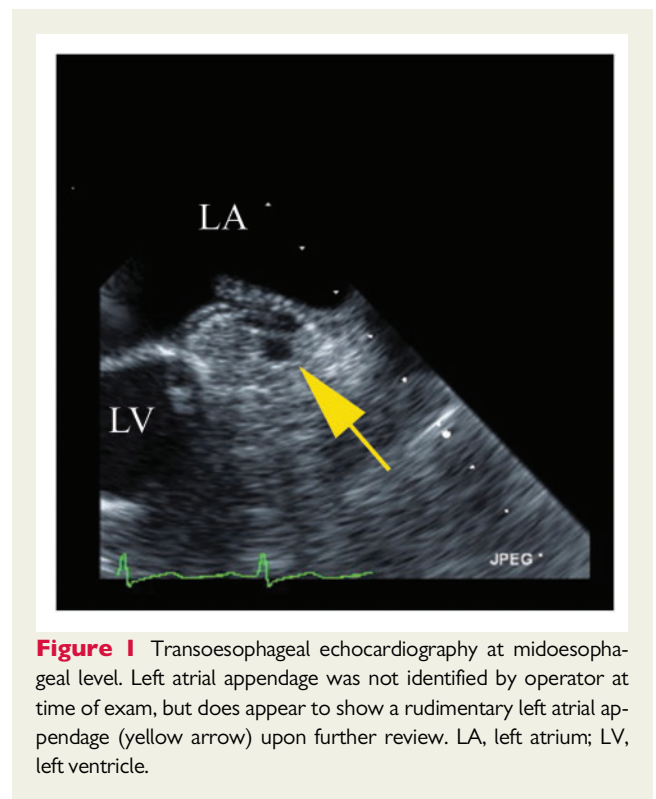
Transoesophageal echocardiography at midesophageal level. Left atrial appendage was not identified by operator at time of exam, but does appear to show a rudimentary left atrial appendage (yellow arrow) upon further review. LA, left atrium; LV, left ventricle.
